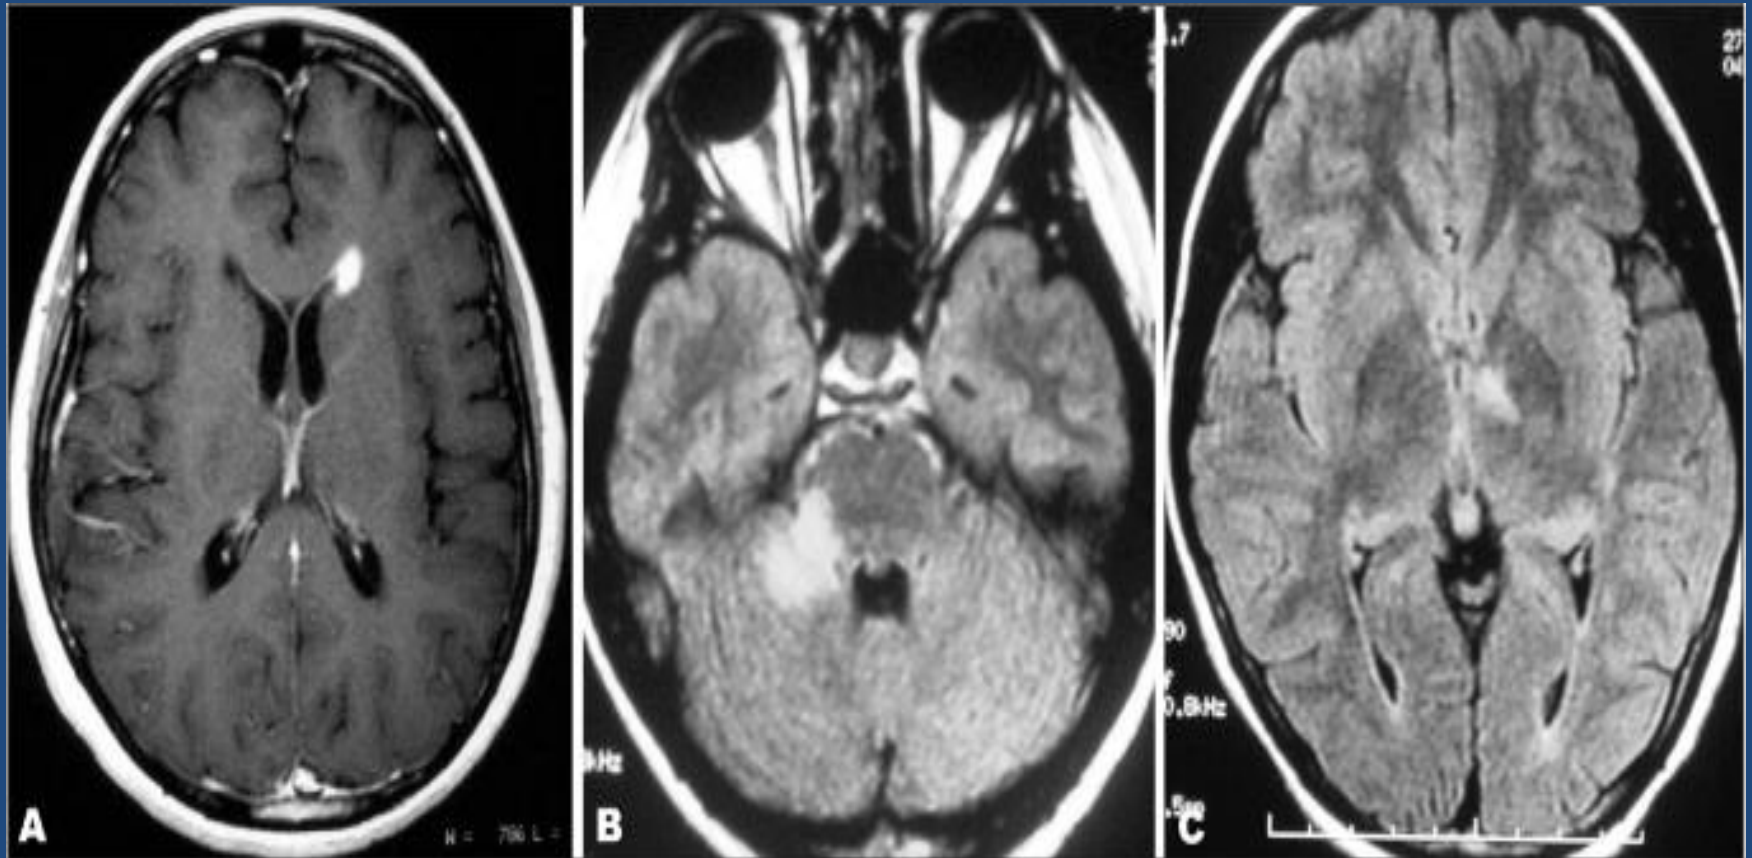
Abnormal brain MRI in patients with neuromyelitis optica. (A) Isolated gadolinium-enhancing periventricular lesion. (B) Tumefactive gadolinium-enhancing lesion involving upper pons and cerebellum. (C) Lesion in the third ventricle region.
